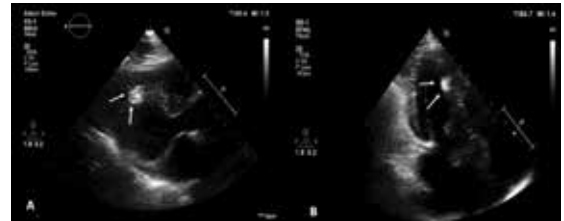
Parasternal short axis view (A) and apical four window view (B) of transthoracic echocardiography showing a hyperechoic mass was originating from in the interventricular septum extending through the left ventricle.
